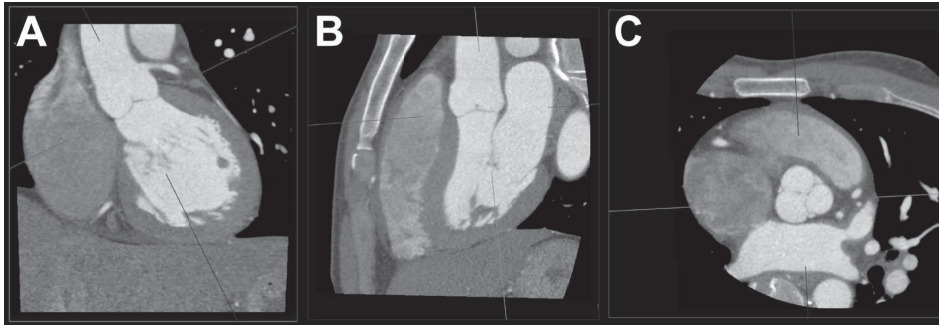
The anatomy of the aortic root was assessed on three reconstructed views. The coronal view (A) is similar to the anterior-posterior view on aortic root angiography. The reconstructed single oblique sagittal (B) view has the same orientation as the parasternal long-axis view on transthoracic echocardiogram and the mid oesophageal long-axis view on transesophageal echocardiogram. The reconstructed double oblique transverse view (C) is parallel to the plane of the aortic root. See Table 1 for detailed description of the variables.
